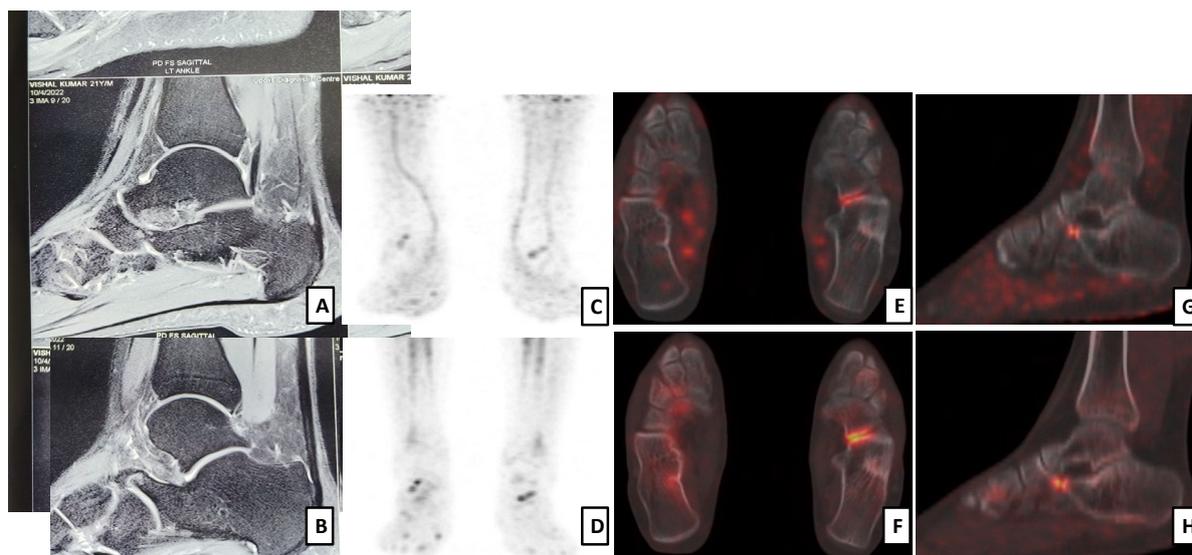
A 21 year old male patient had left foot pain for 5 months. MRI of the left foot (A, B) showed calcaneonavicular coalition and oedema in the calcaneonavicular joint and talus (arrows). Images at 5 minutes (C, E, G) and 45 minutes of ^{18}F NaF PET/CT (D, F, H) images showed increased tracer uptake (SUVmax, early – 2.3, delayed – 7.2) in the left calcaneonavicular joint region (arrows).
